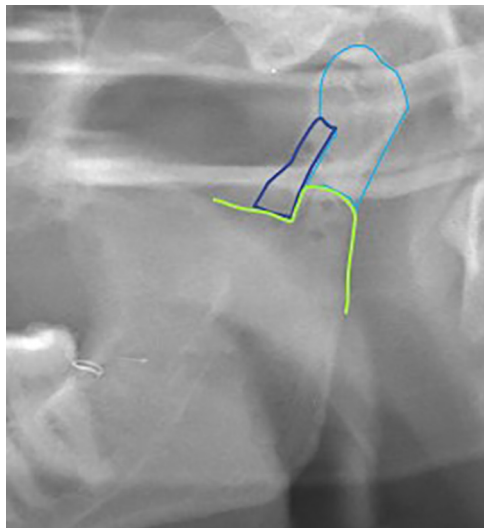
Section of orthopantomogram showing the comminuted fracture pattern and alignment after fixation (case 1).
